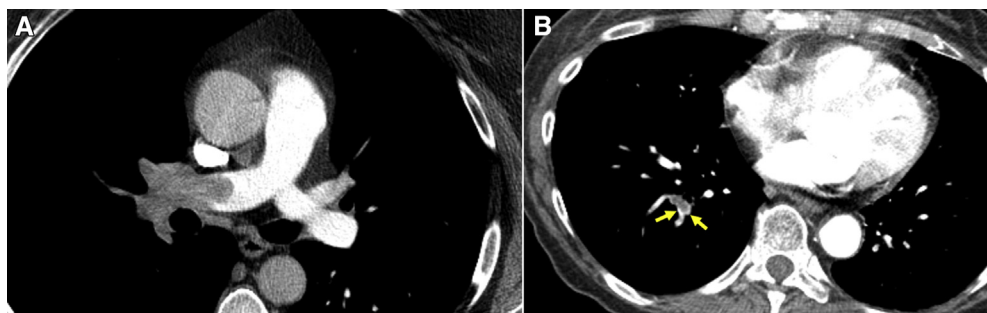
Axial computed tomography pulmonary angiography demonstrating classical pulmonary thromboembolism. (A) Massive central pulmonary embolism with complete filling defect and obstruction of the main right and lobar pulmonary arteries. (B) Segmental pulmonary embolism with partial central filling defect surrounded by a rim of contrast material (arrows) in the right lower lobe.
